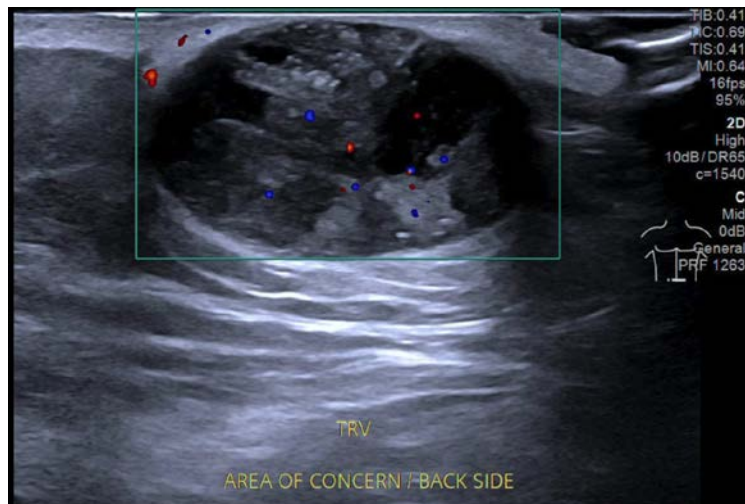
echotexture, hyperechoic area by ultrasound
